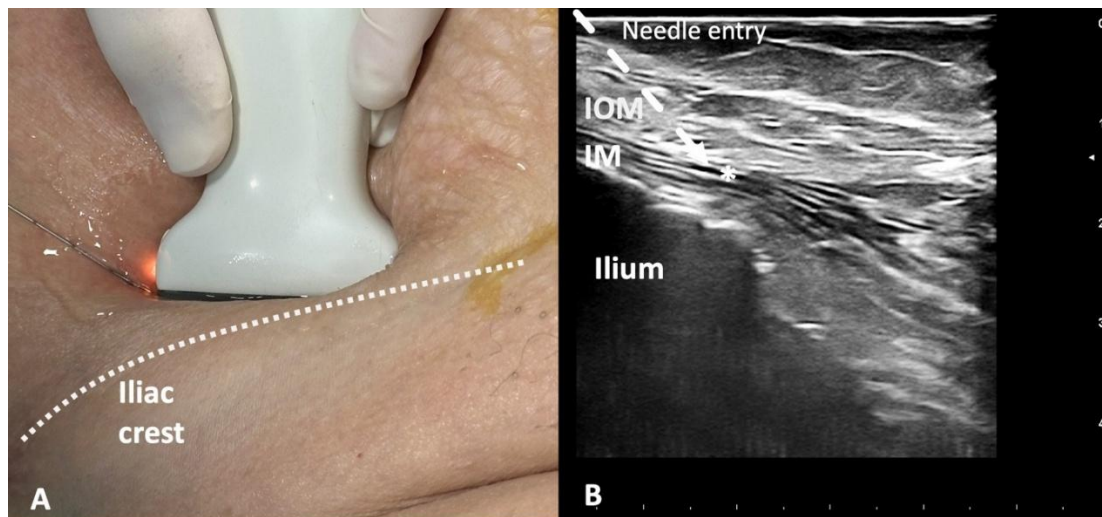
Ultrasound guided anterior iliac block. A: Probe position, B: Ultrasound image, IOM: Internal oblique muscle, IM: Iliacus muscle, *Injection point
